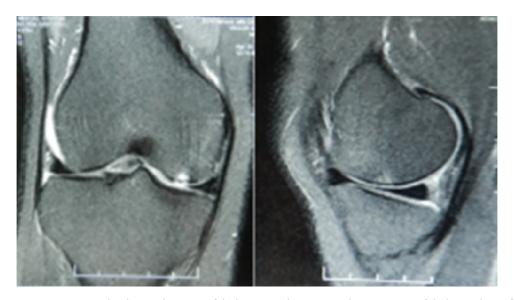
Posttreatment MRI T2W coronal and sagittal sections of the knee joint showing complete resorption of the bone edema after 16 weeks of the combination therapy.
